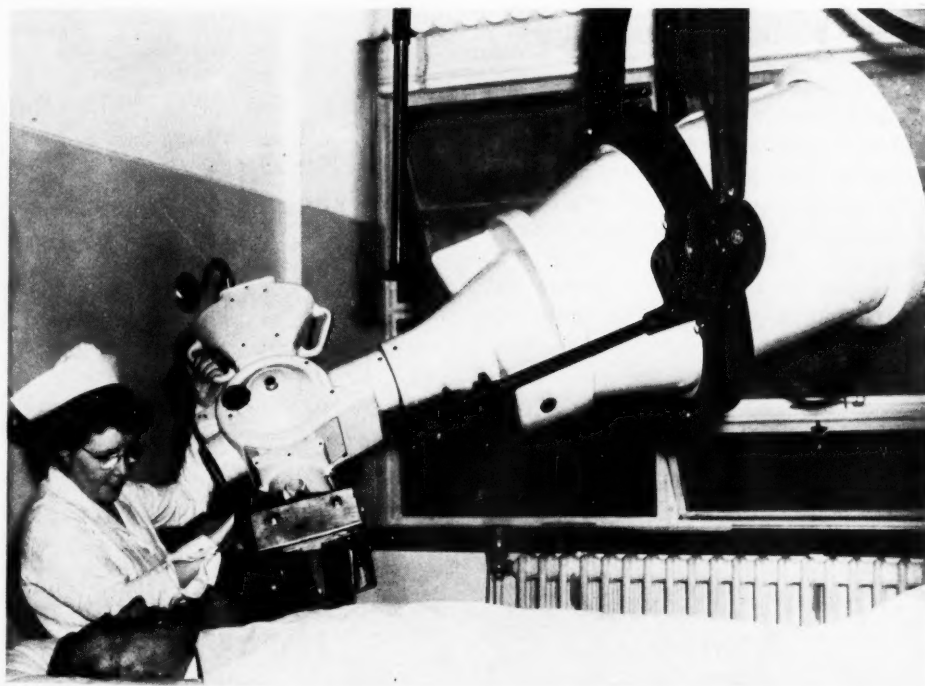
Two hundred and fifty kv.p. resonance transformer x-ray unit.
